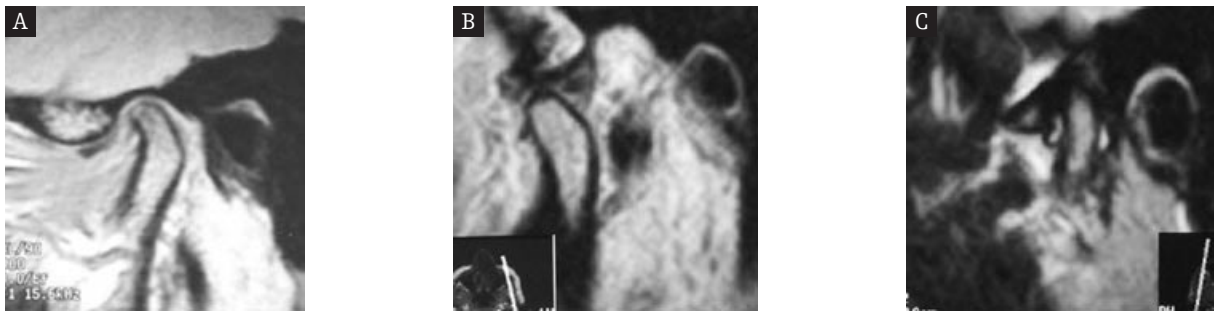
MRI of the TMJ. Mild anterior disc displacement with the reduction during opening. Thinned posterior band. Mild articular exudate. II° in Wilkes score.
